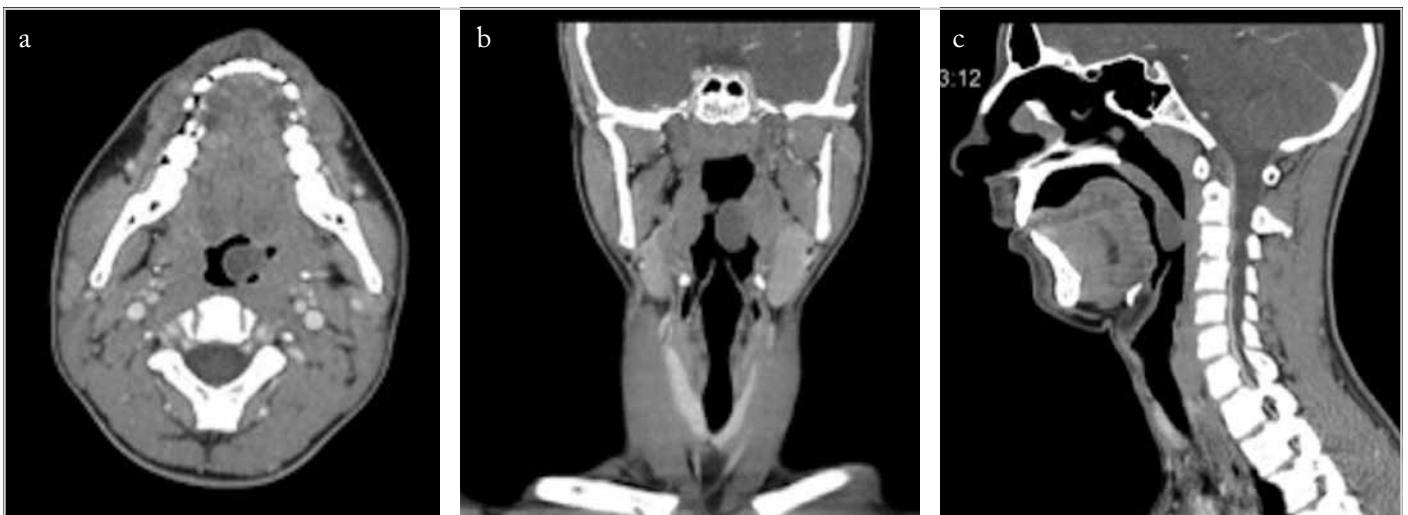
a-c. Axial (a), coronal (b), and sagittal (c) sections of computed tomography of the neck showed a hypodense polypoid lesion in the left tonsillar region extending to the level of the epiglottis just above the oropharyngeal inlet
